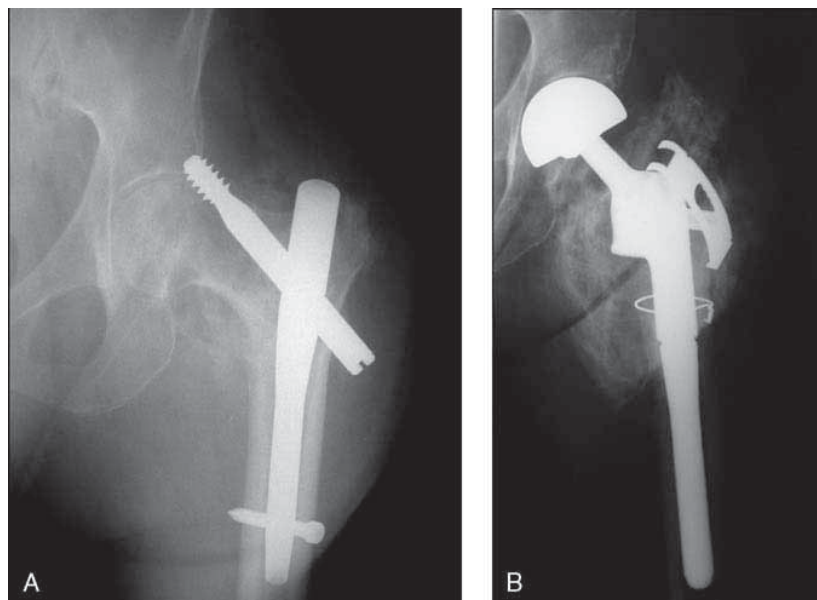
A, Radiograph of an unstable intertrochanteric hip fracture treated with a short intramedullary nail device in a 75-year-old woman. At 4 months, there was screw cutout and failure. B, Because of the bone quality and functional status of the patient, a calcar-replacing hemiarthroplasty was done.
